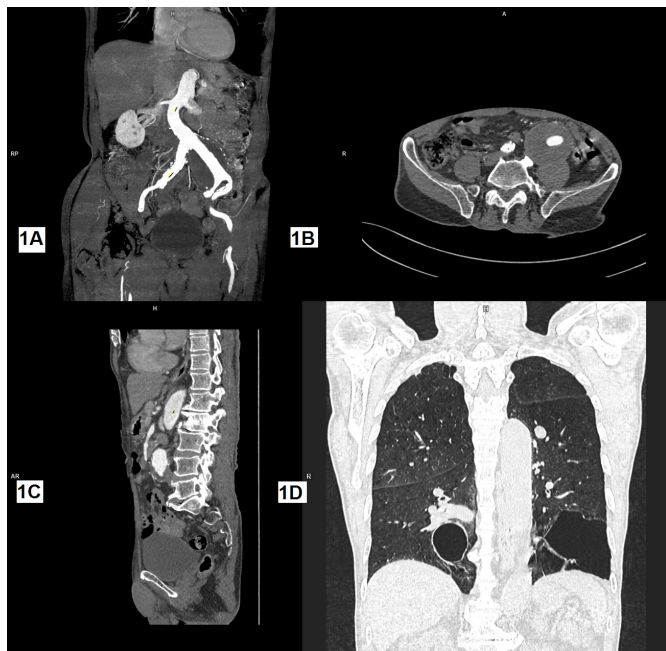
1A) Computed tomography (CT) angiogram coronal section shows large aneurysm involving left common iliac artery; 1B) CT angiogram axial section shows partially thrombosed aneurysm; 1C) CT angiogram sagittal section; 1D) CT chest showing large bullae in the lower lobe of both lungs.
